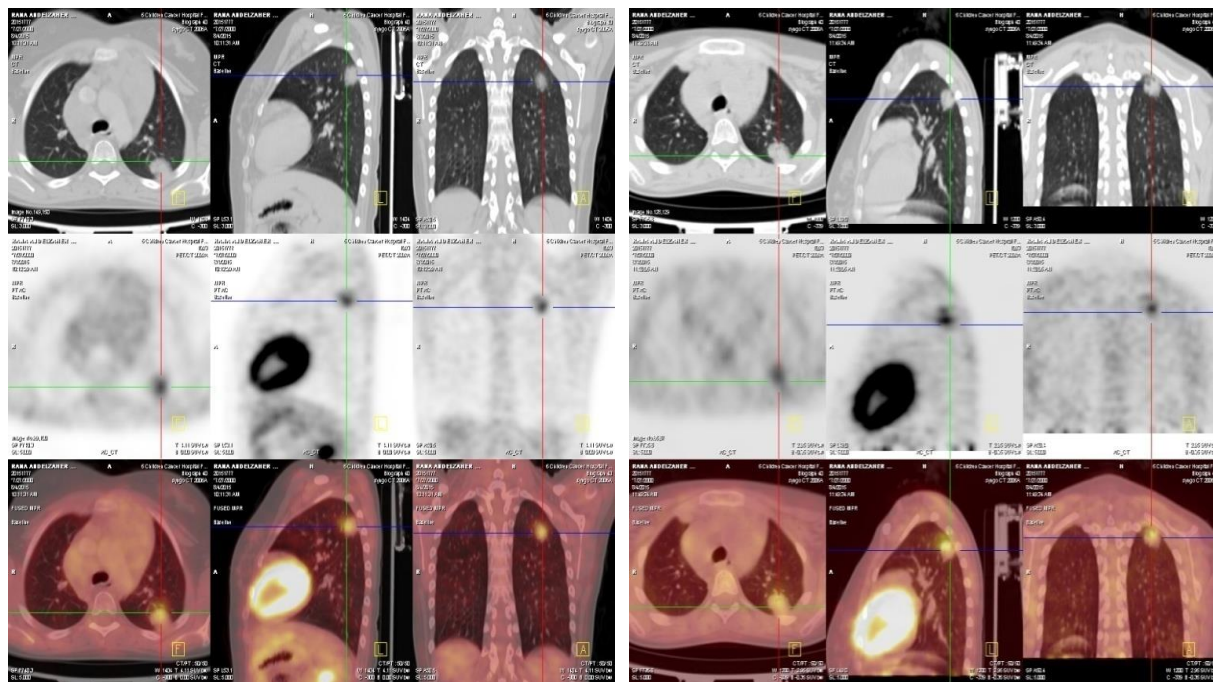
(A): showed FDG avid nodular patch at the posterior segment of left upper lobe with SUVmax~3. (The hepatic reference~4.1).
